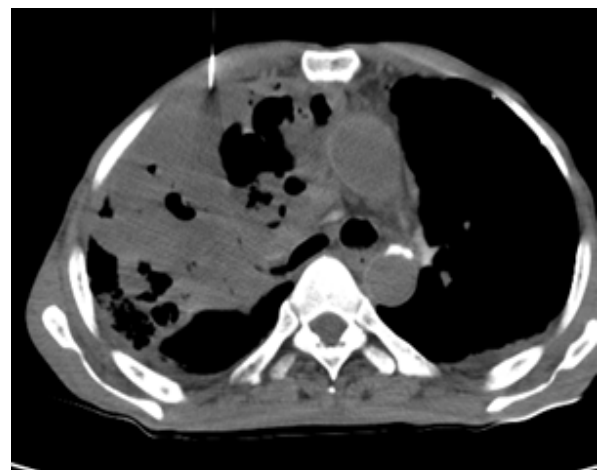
Mass like cavitary consolidation in right upper lobe. Possibility of infective aetiology was given on CT. It proved Squamous Cell Carcinoma on FNAC.
